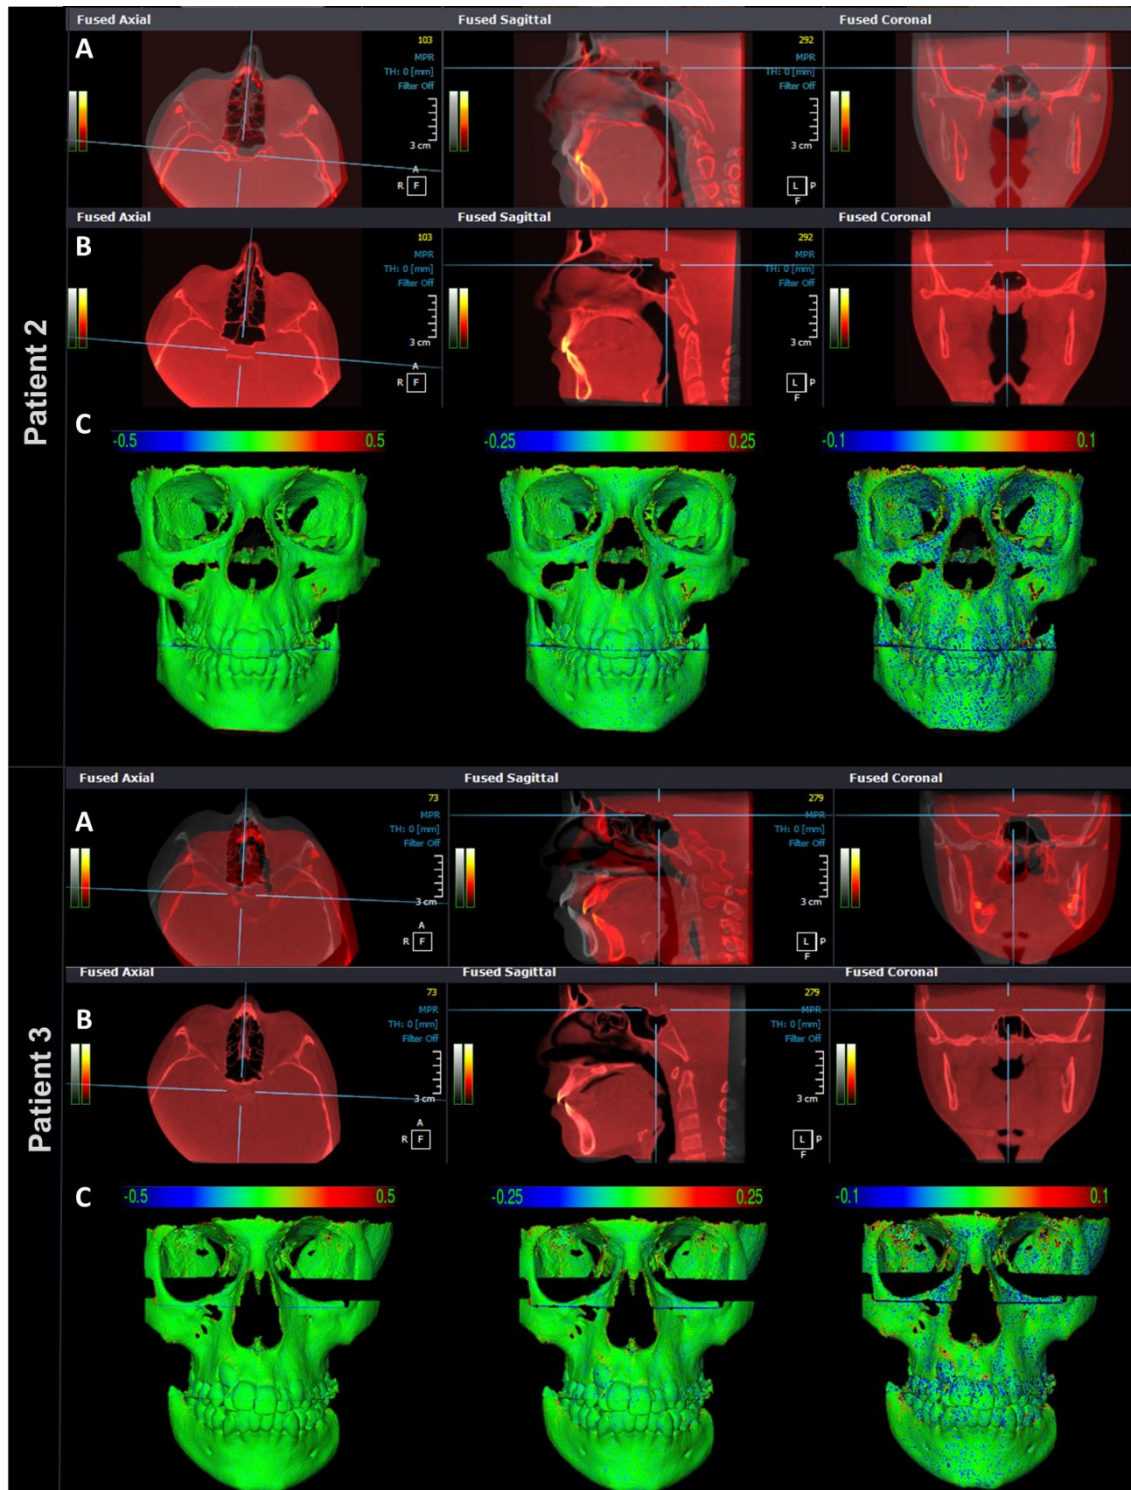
Patients 2 and 3, (A) multiplanar slices of CBCT volumes before cranial base superimposition and (B) after cranial base superimposition, in Ondemand3D, showing the complete correspondence of registration in all areas (C) Skull models after superimposition showing 3D displacements (registration error) via color maps with scale of 0.5mm, 0.25mm and 0.01mm. Positive and negative values indicate outward (red) and inward (blue) changes, respectively. Note the error was less than 0.25mm (CMF application software).
